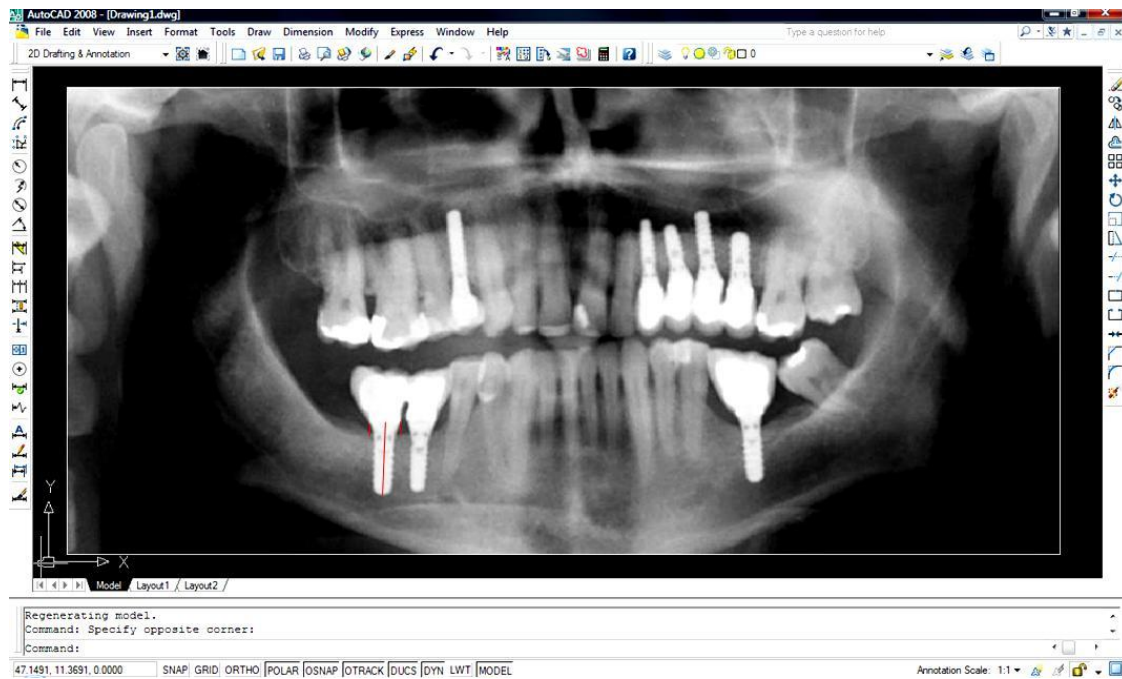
Panoramic radiograph manipulated by the computer program in preparation for measurement.
